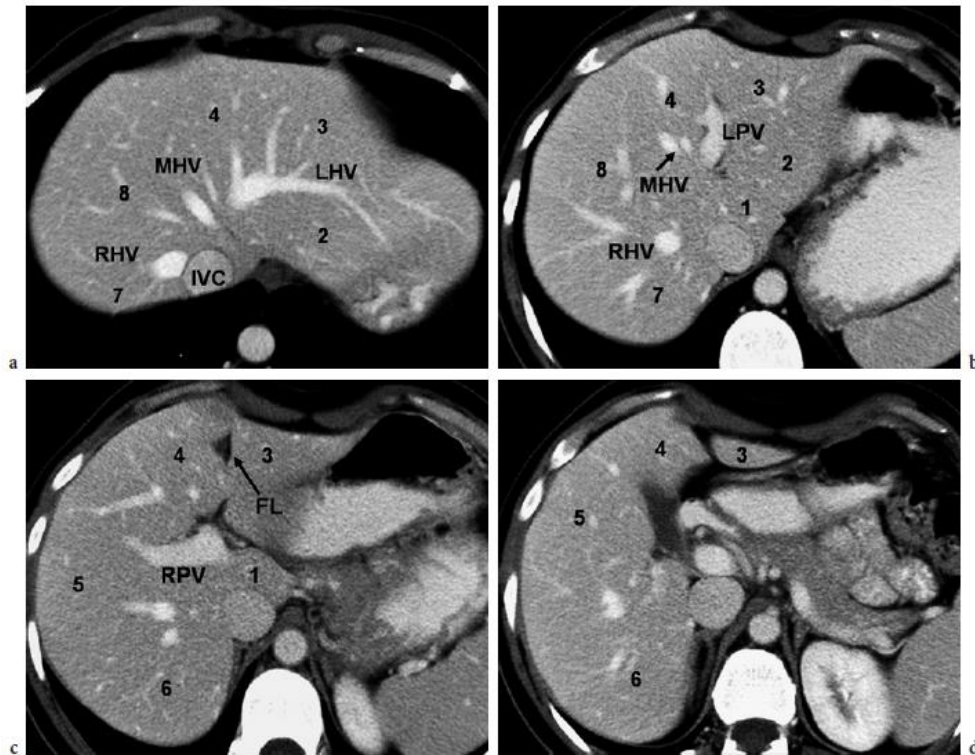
(a–d). CT scan through the liver with Couinaud's segments divided and numbered. RHV, right hepatic vein; MHV, middle hepatic vein; LHV, left hepatic vein; IVC, inferior vena cava; RPV, right portal vein; LPV, left portal vein; FL, falciform ligament (Majno et al., 2005).
